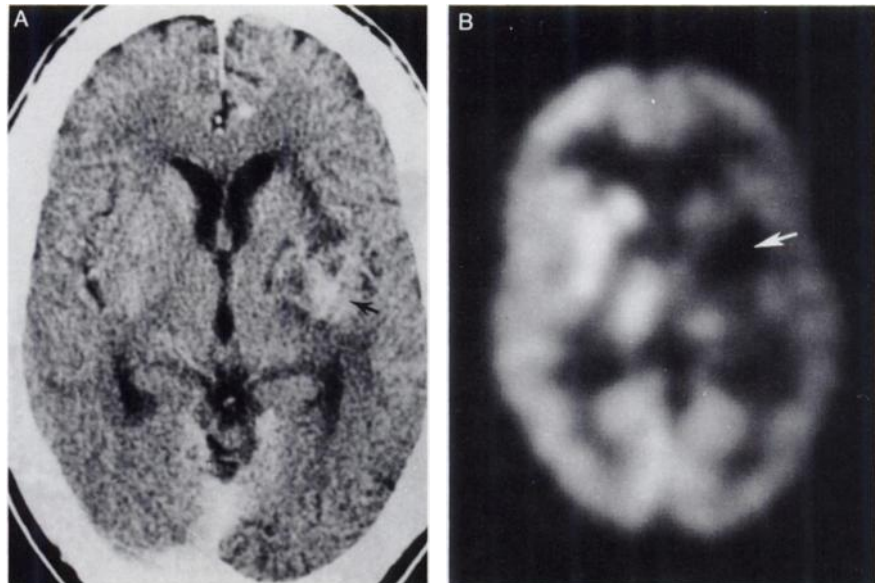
Patient 1 (Table 1). Enhanced CT scan (A) shows a left subcortical enhancing lesion (arrow). FDG-PET study (B) shows a hypometabolic abnormality in the left subcortical region (arrow). This patient had toxoplasmosis.
